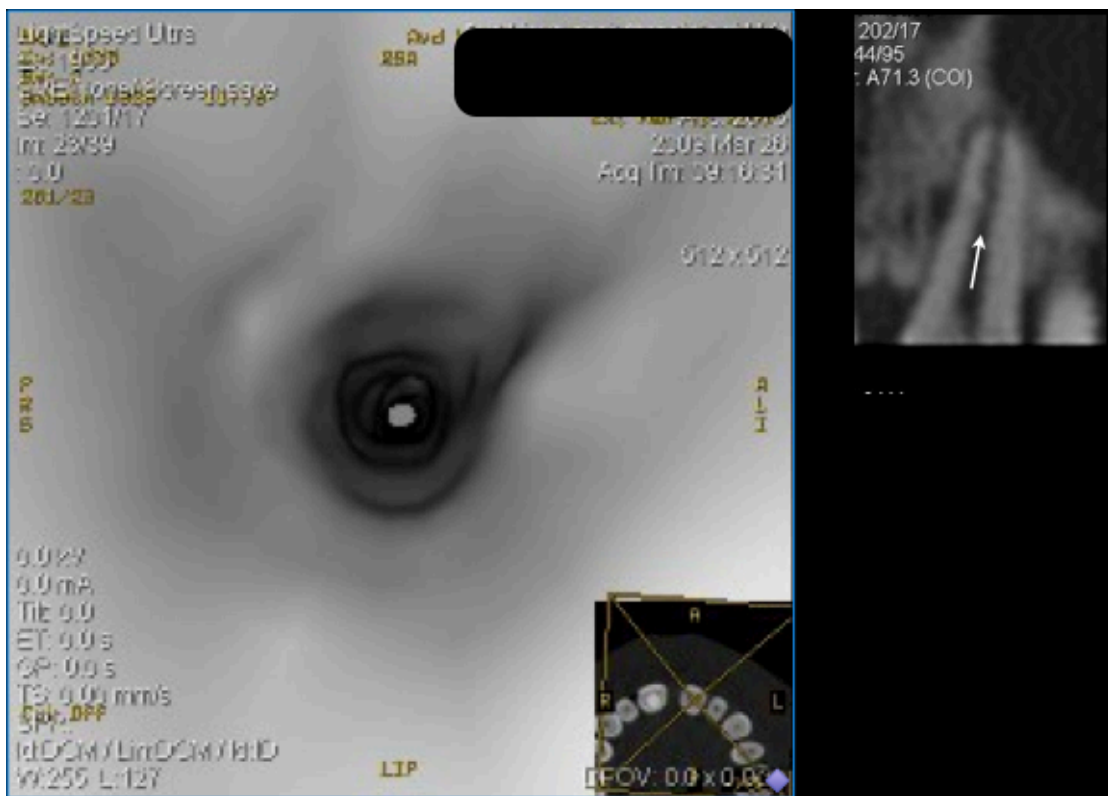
Axial CT Maxilla
